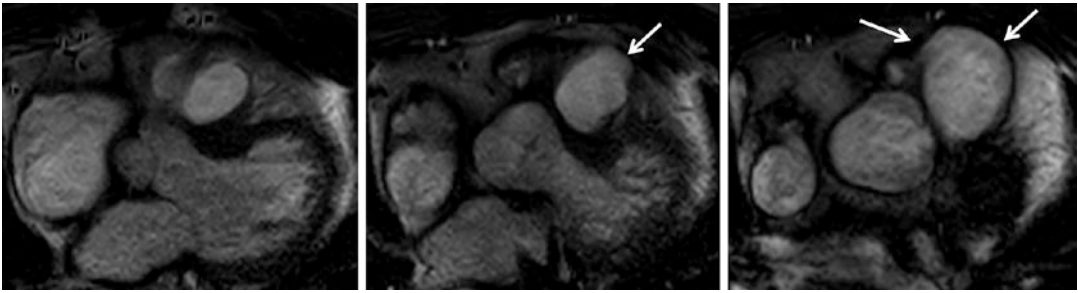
Fifty-six-year-old male with corrected TOF. MRI bright blood (SSFP) images in three adjacent axial views of the RVOT, showing an aneurysm (*arrows*). SSFP cine
